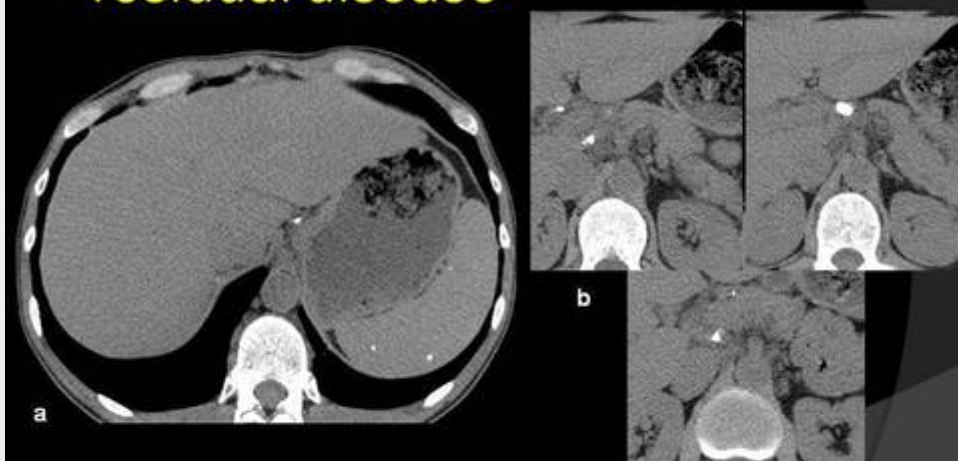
Man, 45 years old, with history of splenic and lymph node tuberculosis. Abdominal CT before iv contrast shows small calcified granulomas in spleen (a) and calcified lymphadenopathy, namely in the peripancreatic area (b).
